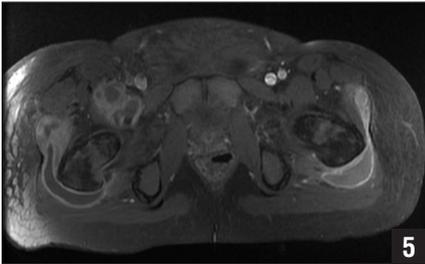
Axial T1-weighted pelvis magnetic resonance image with gadolinium revealing contrast enhancement of the right and left gluteal musculature, with an abscess on the right just posterior to the rectus femoris. Note the increased signal in the subcutaneous tissues and along the fascial planes on the right side, indicating fasciitis.
